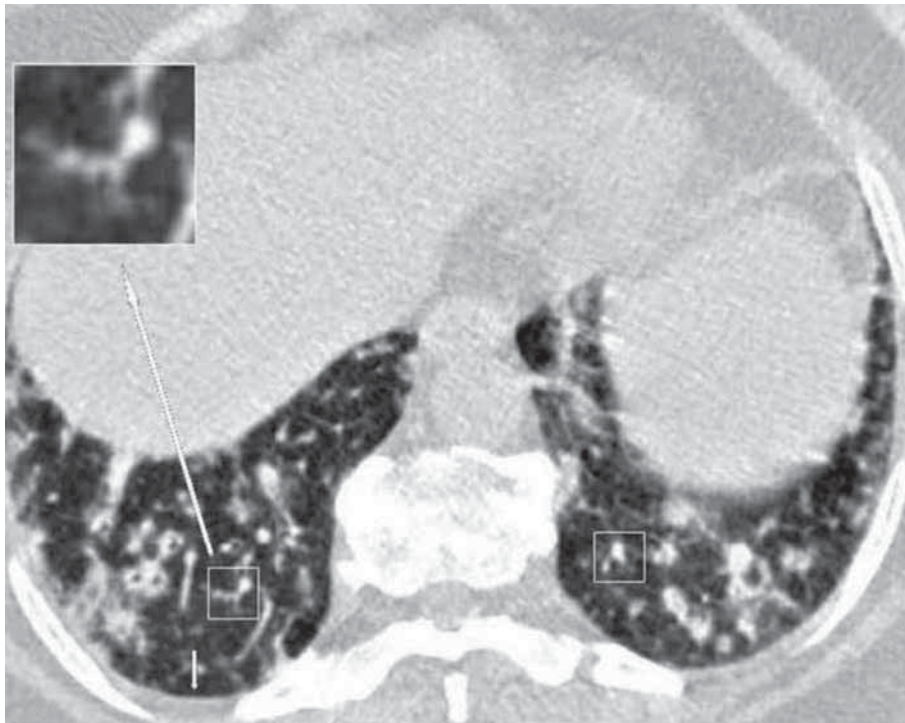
A 56-year-old female patient with known type 2 diabetes mellitus presented on day 4 of symptom onset with nausea, fatigue and dyspnea. The patient was admitted for inpatient care when she exhibited clinical progression. In her follow-up, CT-SS was 28, and lower lung lobes showed tree-in-bud appearance (squares) and mild pleural effusion (little arrow), which prompted consideration of superinfection with another pathogen.
